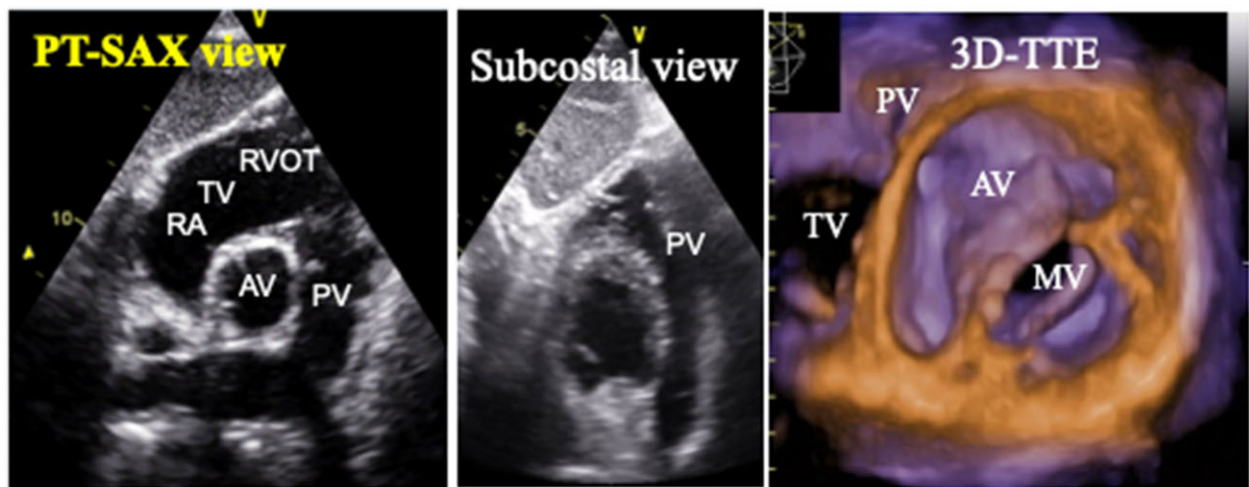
2D and 3D echo recordings of the pulmonic valve. PT-SAX, parasternal short-axis view.
